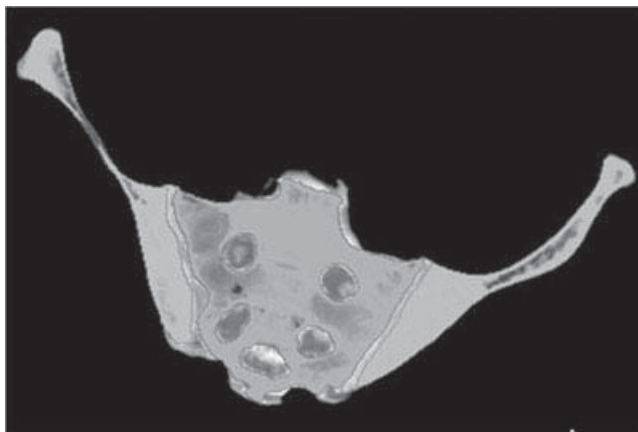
CT segmentation of pelvic regions. An axial CT image slice at the level of the ilium showing the segmentation of the right ilium, left ilium, sacrum, and sacroiliac joint. The segmentation was used to generate subject-specific geometry for the FE model and to assign location-dependent material property for interior bone based on CT intensity
